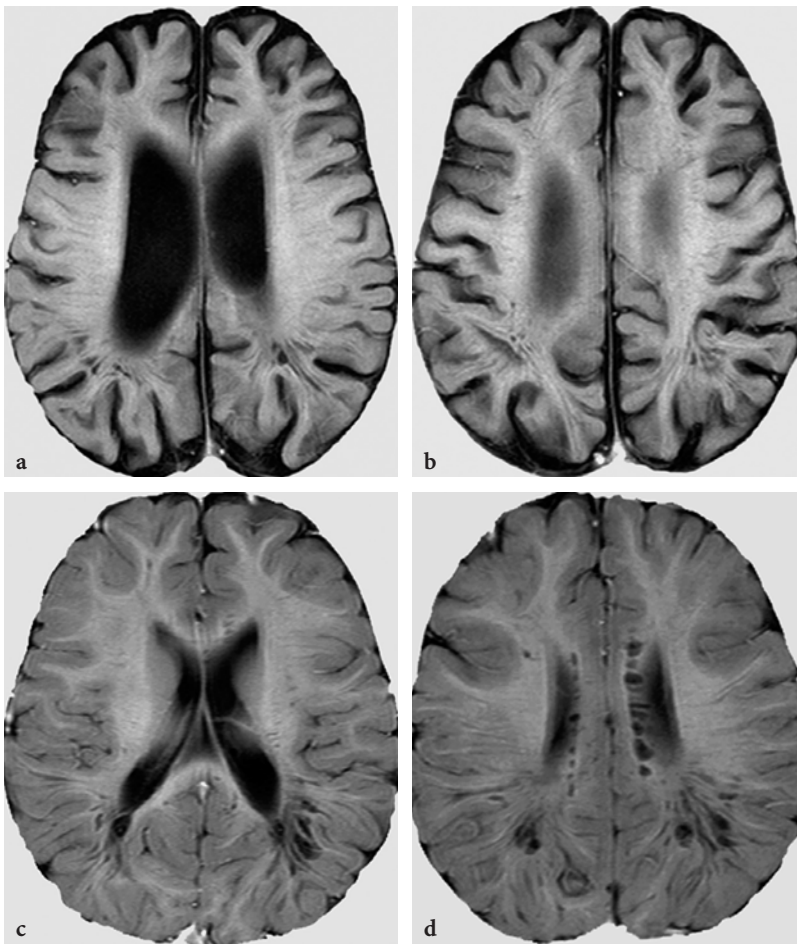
a–d. Enlarged perivascular spaces in various forms of mucopolysaccharidosis on T1-weighted inversion recovery images. a, b 5-year-old female patient with Sanfilippo disease. c, d 2.5 year-old male patient with Hunter disease
